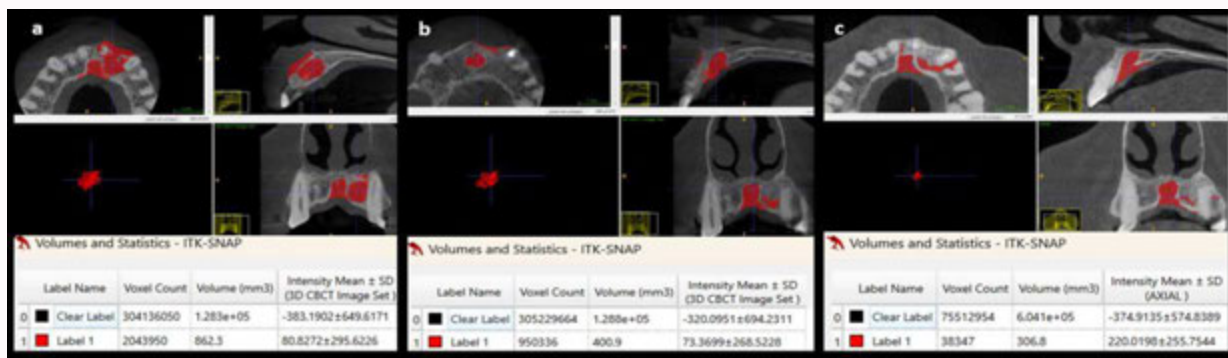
Case 5. a) Preoperative CBCT Volumetric analysis using ITK-SNAP Software, b) First follow-up CBCT Volumetric analysis using ITK-SNAP Software, c) Second follow-up CBCT Volumetric analysis using ITK-SNAP Software.
